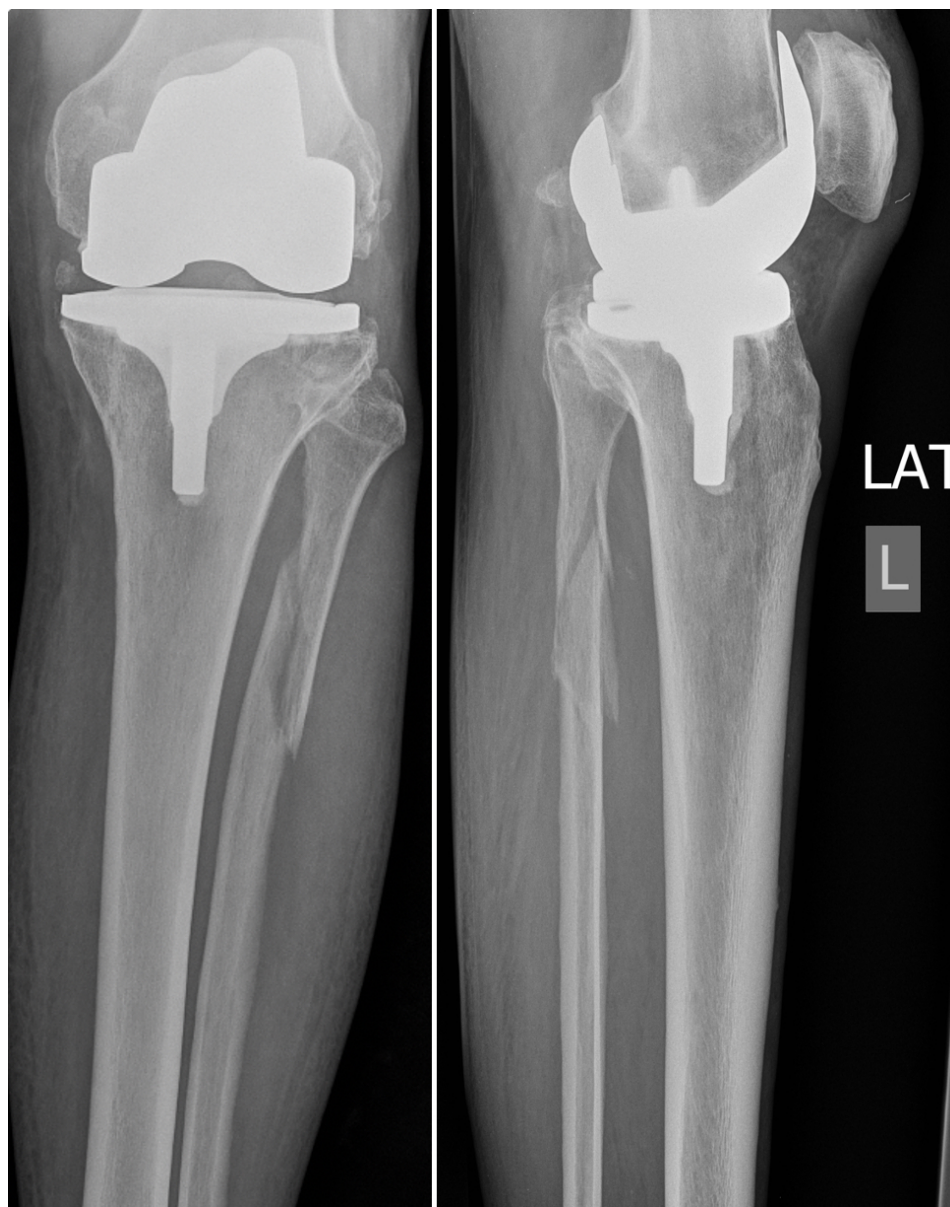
AP and lateral radiographs of the left knee and proximal tibia and fibula demonstrating proximal fibular fracture consistent with Maisonneuve fracture mechanism.
